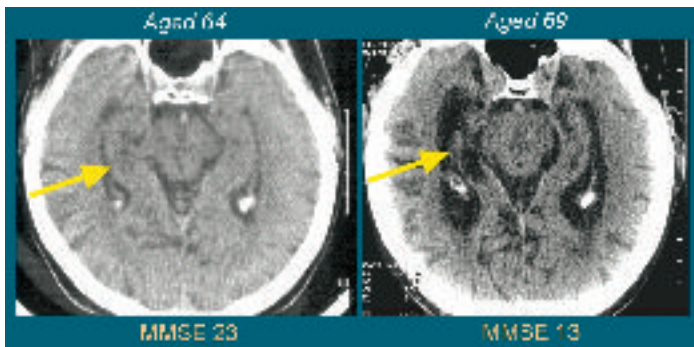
Computed Tomography (CT) scan of a patient with confirmed Alzheimer's disease. Shrinkage of the hippocampus (arrowed) strikingly parallels cognitive decline as assessed by the Mini-Mental State Exam (MMSE) score.
